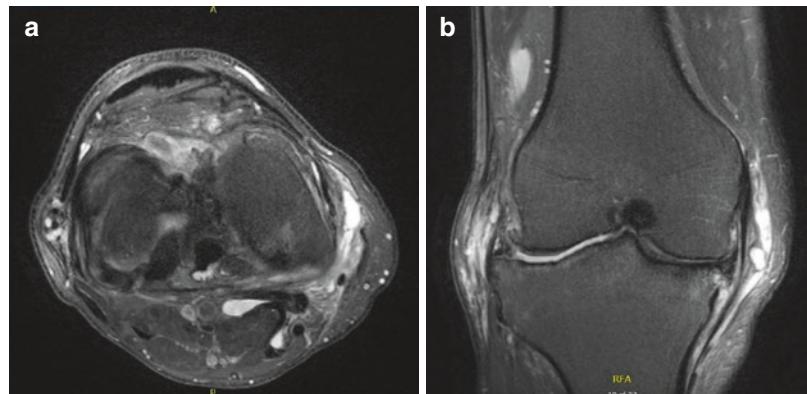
Representative T2-weighted magnetic resonance (MR) (a) axial and (b) coronal images demonstrating complex posterolateral meniscus tear with associated parameniscal cyst extruding into the lateral soft tissues and through a torn portion of the posterior aspect of the iliotibial band at the level of the joint line
